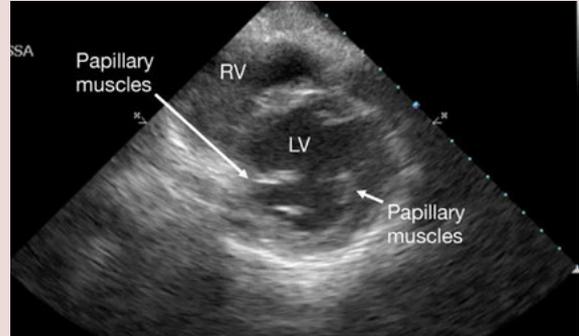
Parasternal short view: LV = left ventricle.
